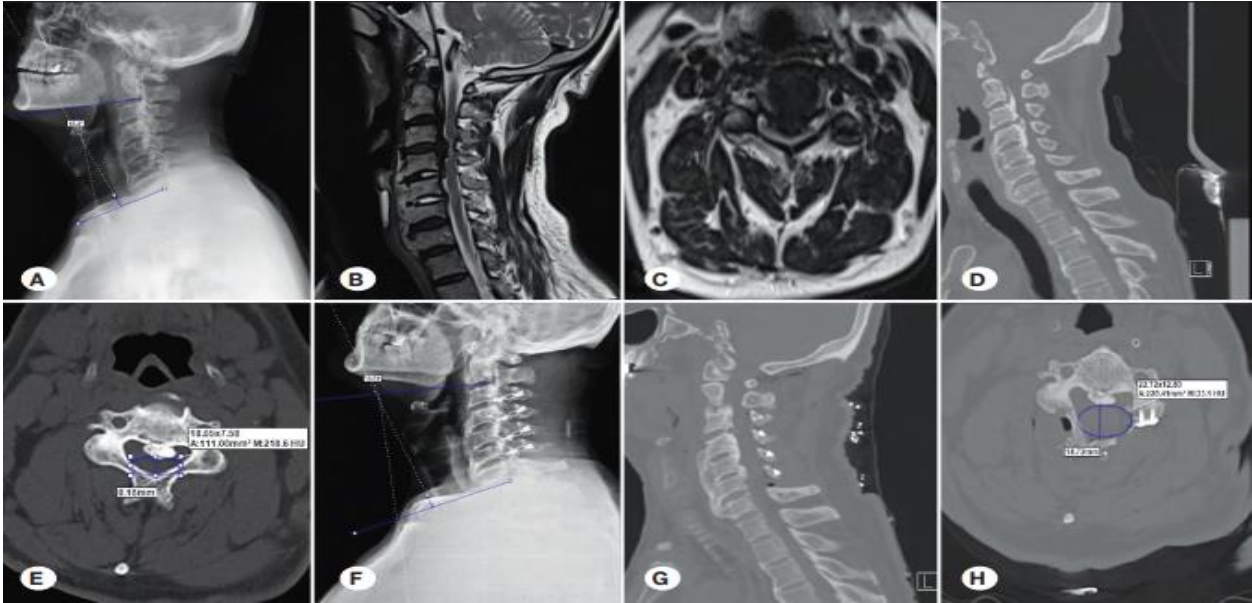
A preoperative radiograph (LP) (A) MRI; (B) MRI, sagittal; (C) MRI, axial; (D) CT, sagittal; (E) CT, axial; (F) CT; (G) CT, sagittal and (H) CT, axial
